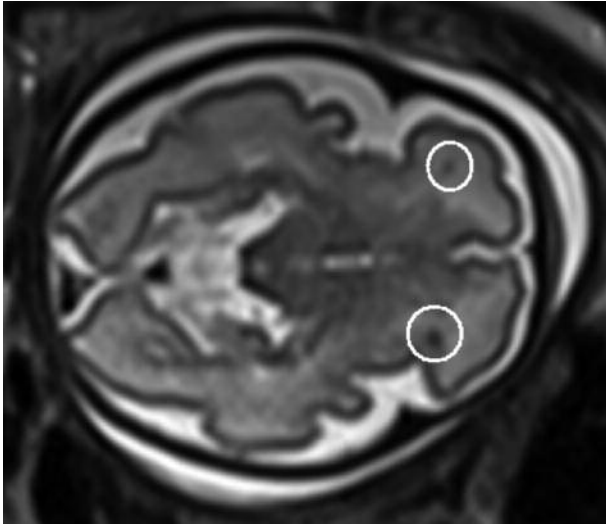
MRI axial view of subcortical tubers in both frontal lobes (encircled in white) in a fetus (gestational age 32 weeks) with multiple cardiac rhabdomyomas. Tentative diagnosis of tuberous sclerosis.
